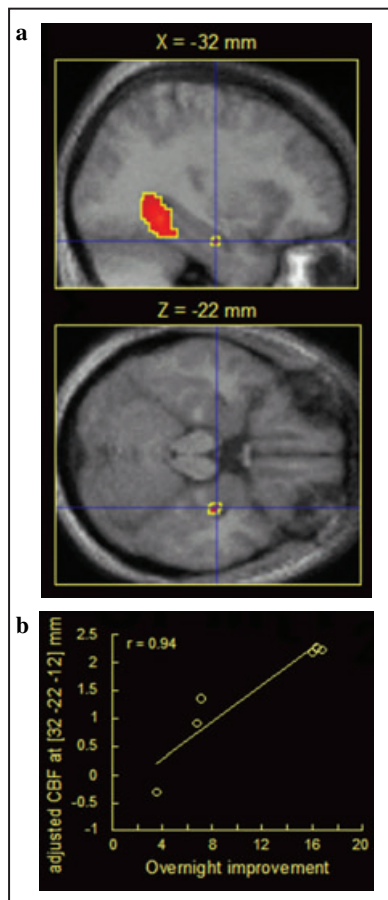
Hippocampal reactivation during slow-wave sleep and consolidation of spatial episodic memories. (a) Regression between regional cerebral blood flow increases during SWS and overnight improvement in performance (distance left to the target in presleep minus postsleep session) superimposed on sagittal (top) and transverse (bottom) cross-sections of the average T1-weighted MR image. Activations are located in the right parahippocampal gyrus (top cross-section) and right hippocampus (visible on both cross-sections). Adapted with permission from Peigneux *et al.* (2004).
